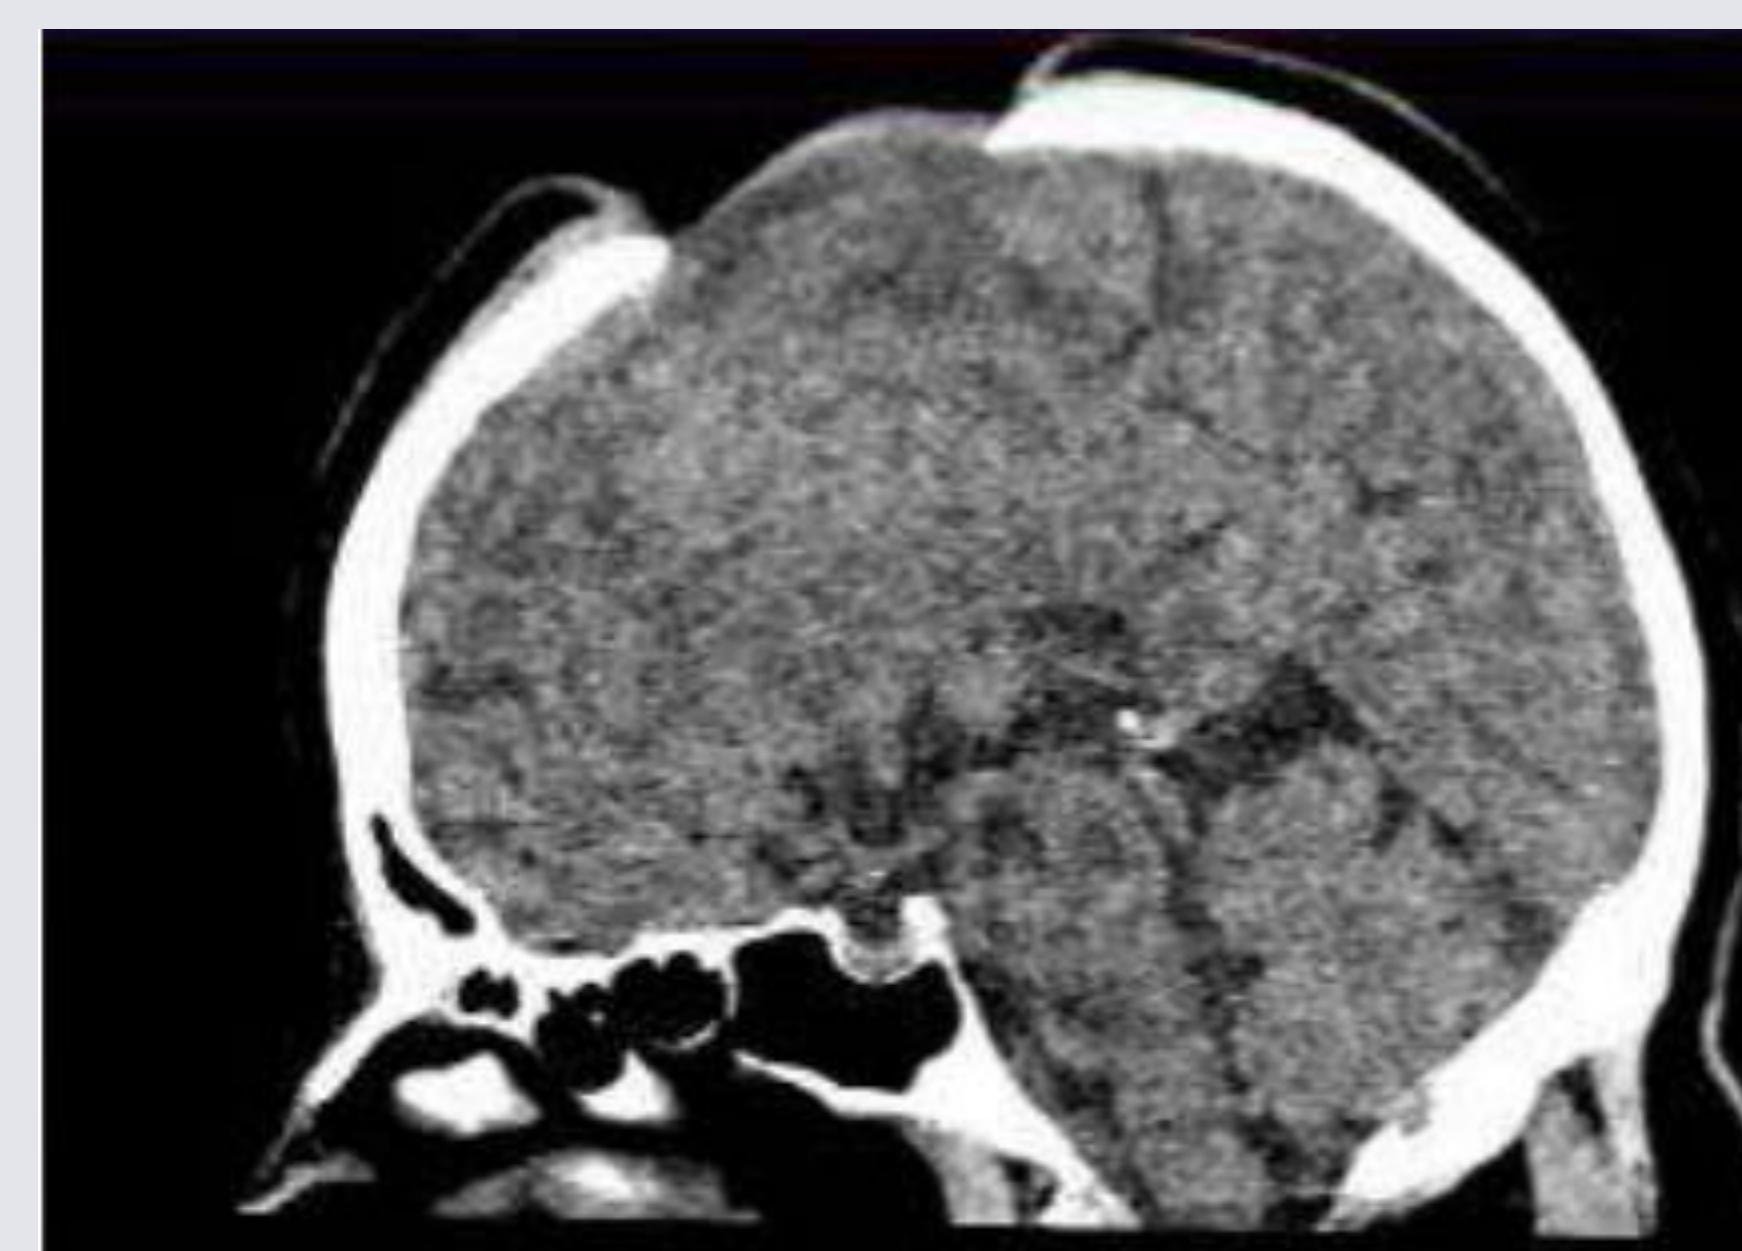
CT Head – Sagittal view
